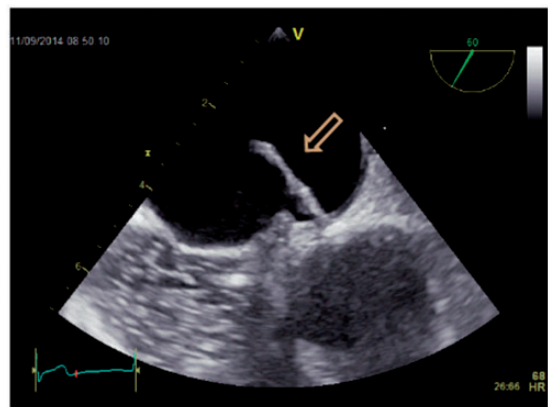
2D transesophageal echocardiography of a displaced atrial septal occluder (arrow). Test with isotonic solution of agitated saline water.
